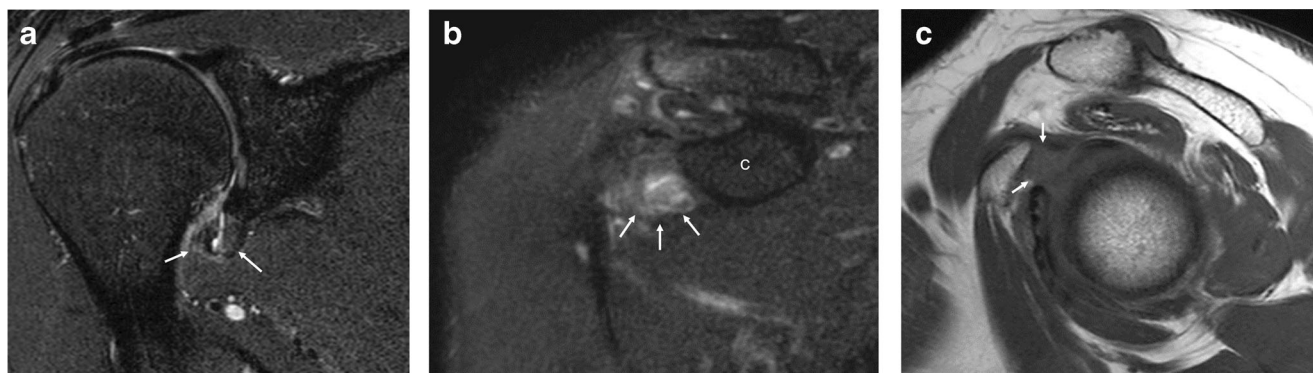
Example evaluations of qualitative MR findings. a A 47-year-old woman with adhesive capsulitis. Oblique coronal fat-suppressed T2-weighted image showing axillary capsular thickening and abnormal hyperintensity. Increased thickness at the glenoid (4.71 mm) and humeral (5.69 mm) portion and T2 signal intensity of axillary joint capsule
